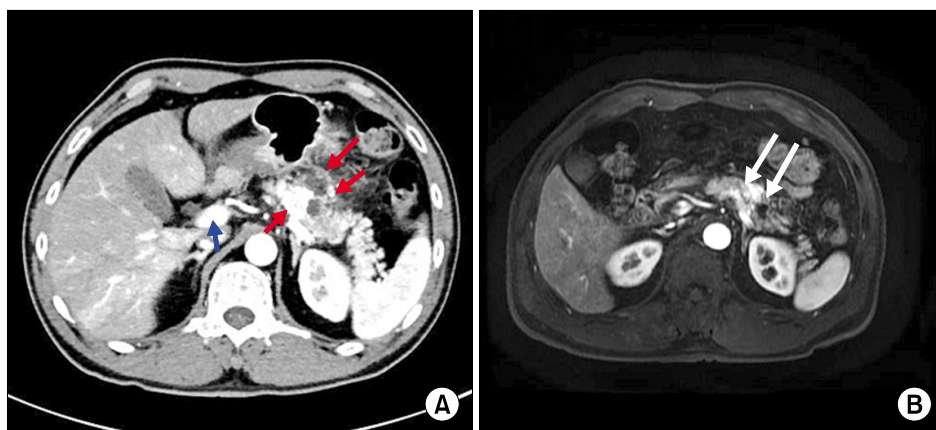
Arterial phase contrast-enhanced computed tomography showed high density lesions of about 1.5-2.0 cm in diameter with tortuous vascular structure. Fluid collection was located at the distal portion of the vascular structure, with fat stranding around it (A, red arrows). The supplying artery is not clear, but early drainage is seen to the portal vein during the arterial phase (A, blue arrows). Magnetic resonance imaging showed intermediate a signal intensity lesion with cystic portion of the pancreatic body, without distal pancreatic duct dilatation (B, white arrows).
